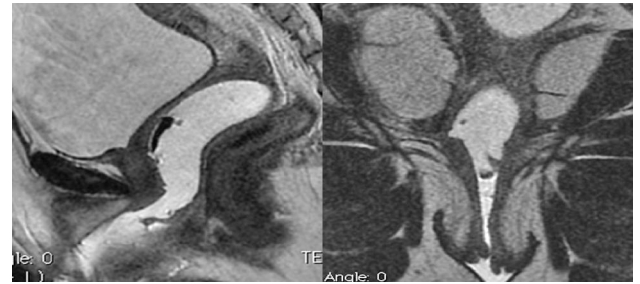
MRI T2 weighted Sagittal and Coronal Images: Endovaginal gel instillation technique demonstrates a thin partial vaginal septum along distal aspect. A tiny defect is identified within the septum anteriorly representing a non-obstructed vaginal septum.
